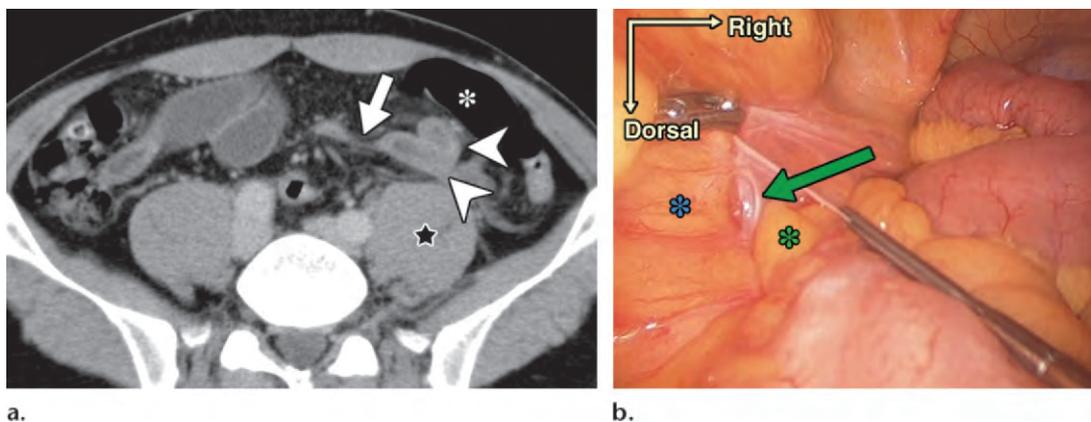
Intersigmoid hernia in a 37-year-old man with sudden-onset left lower abdominal pain. (a) Axial contrast-enhanced CT image shows closed-loop intestine (arrowheads) and a hernia orifice (arrow) between the sigmoid colon (*) and left psoas major muscle (*). (b) Intraoperative photograph (superior view) during laparoscopic surgery after reduction shows a 1-cm-diameter defect (green arrow) where the root of the sigmoid mesocolon (blue *) attaches to the parietal peritoneum (green *). The hernia orifice was surgically closed. (Fig 16a courtesy of Sho Toyoda, MD, Bell Land General Hospital, Sakai, Japan. Fig 16b adapted and reprinted, with permission, from reference 59.)
